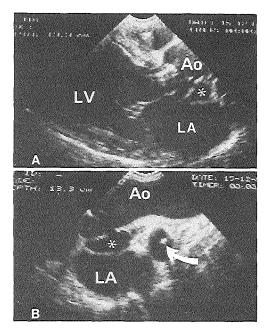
Intraoperative epicardial two-dimensional echocardiograms obtained in a patient (Table I, Patient 3) with infective endocarditis of aortic valve. A, Left ventricular long-axis view, obtained with transducer placed on right ventricular outflow tract, demonstrated unsuspected supraannular aneurysm in left coronary sinus (asterisk). B, Transducer positioned on ascending aorta (A0) revealed size of aneurysm (asterisk). Note Swan-Ganz catheter in right pulmonary artery (arrow). LA. Left atrium. LV, Left ventricle.
